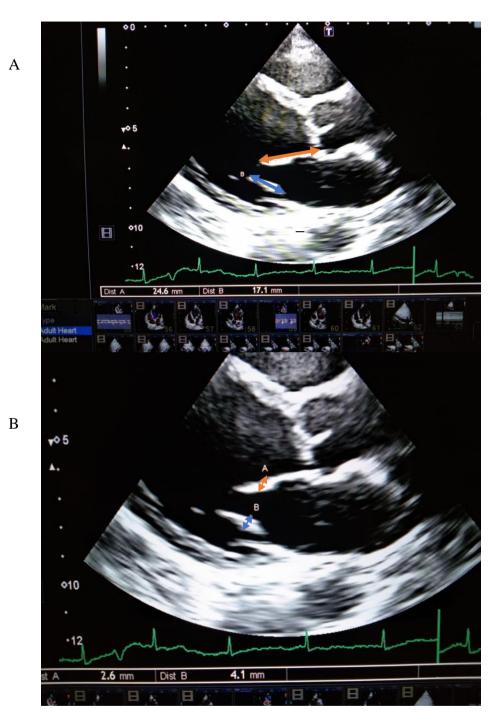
Echocardiographic image of PLAX view measuring (A) anterior (orange arrow) and posterior (blue arrow) leaflet length (B) anterior (orange arrow) and posterior (blue arrow) leaflet thickness from the current study conducted at NICVD, Karachi.
